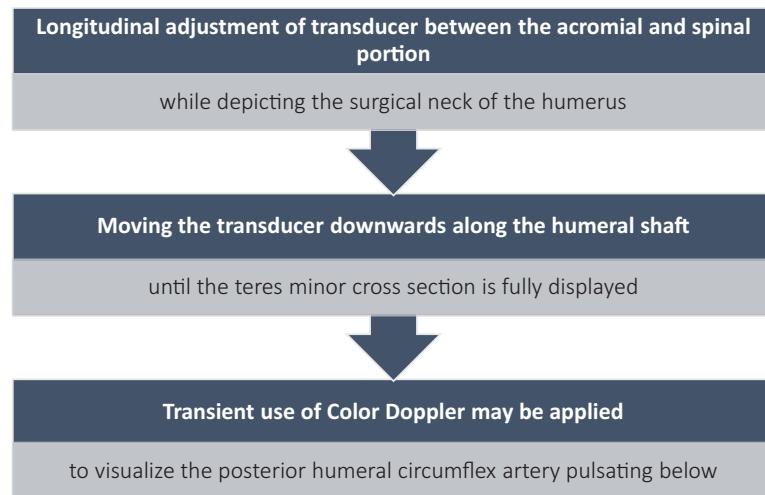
Adjustment of the primary scan plane preceding contrast-enhanced ultrasound examination of the deltoid muscle tissue.
